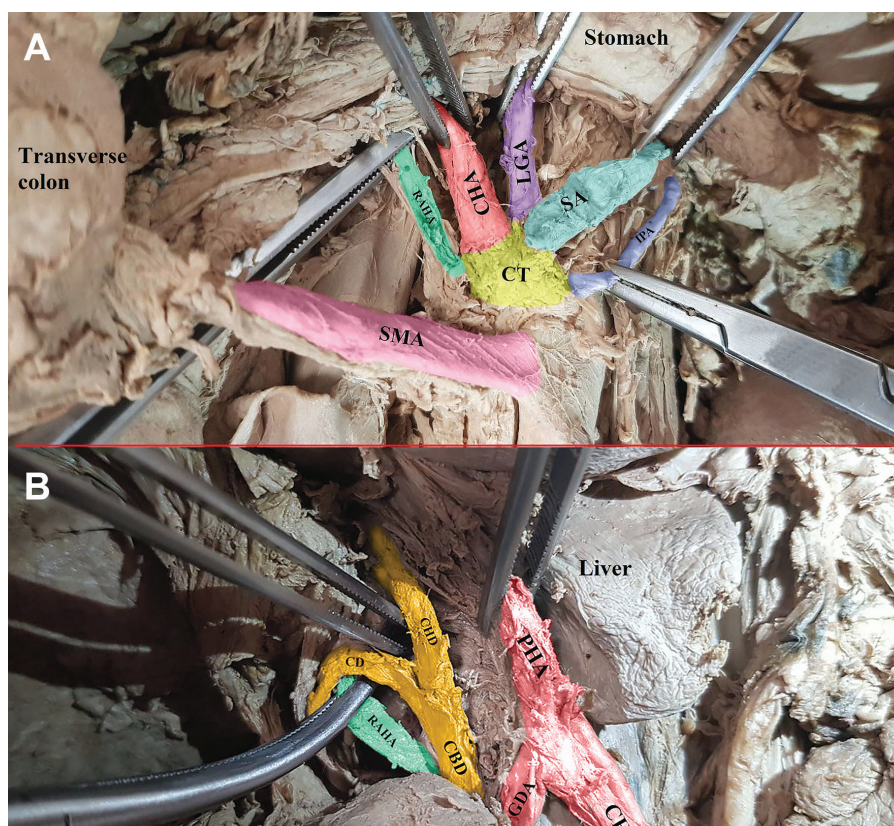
Special pattern of the celiac trunk (CT) and accessory hepatic artery is shown. (A) The CT in special pattern pentafurcates to the inferior phrenic artery (IPA), splenic artery (SA), left gastric artery (LGA), common hepatic artery (CHA), and right accessory hepatic artery (RAHA). The superior mesenteric artery originates from the abdominal aorta, slightly lower than the CT origin. (B) Accessory hepatic artery ascends behind the bile duct to provide blood supply to the liver. GDA: Gastroduodenal artery; PHA: Proper hepatic artery; CBD: Common bile duct; CHD: Common hepatic duct; CD: Cystic duct
